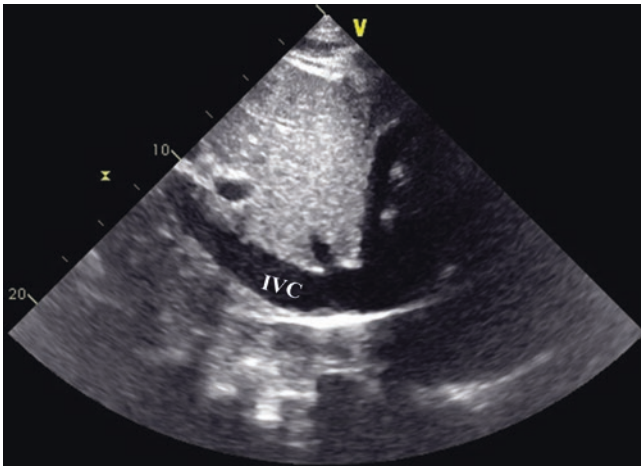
Inferior vena cava and estimation of the right atrial pressure. Inferior vena cava (IVC) assessment is essential when evaluating a patient for cardiac tamponade. Dilated (>2.1 cm) inferior vena cava with little collapsibility (<50%) suggests elevated systemic venous pressures and it is a sensitive (but not specific) sign for pericardial tamponade. M-mode echocardiography can also be used to assist in documenting inferior vena cava size and collapsibility
